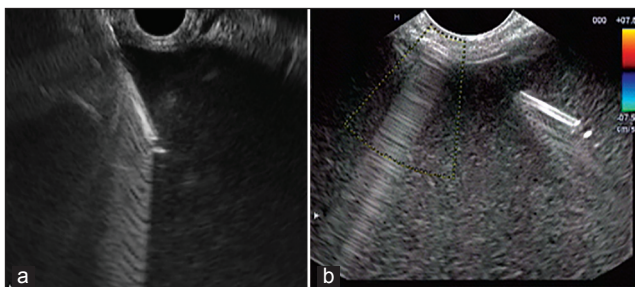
(a) Endoscopic ultrasound (EUS)-guided puncture of the pseudocyst using 19-gauge needle. (b) EUS-guided puncture of the pseudocyst using 19-gauge needle. Color Doppler is used to ensure blood vessel free tract
